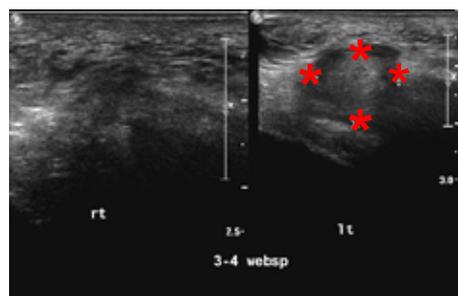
Morton's neuroma. Cross sectional ultrasound images comparing the appearances of a normal web space between the 3rd and 4th metatarsals on the right and the 3-4 web space with a large neuroma (calipers) on the left.
